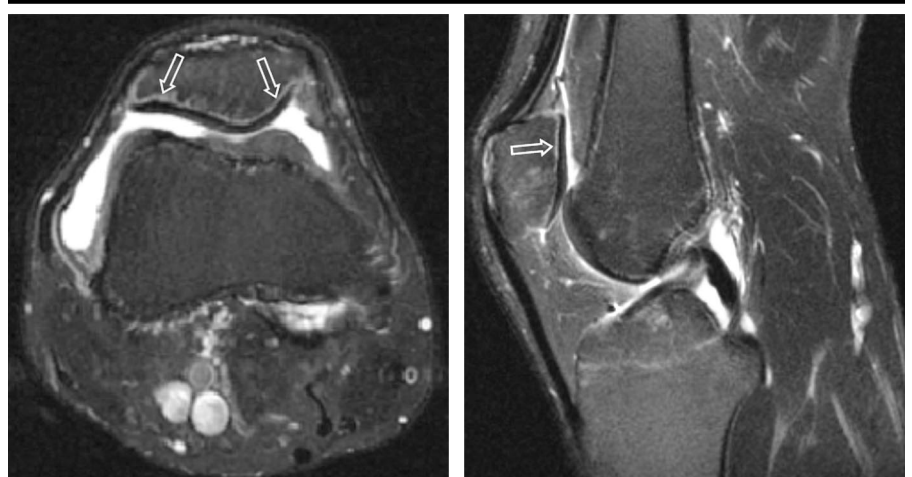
(a) Transverse and (b) sagittal T2-weighted fast SE MR images obtained with fat saturation (3500/68.4) in a 30-year-old man who was assessed for clinically suspected ACL injury. Increased peripheral signal intensity (arrows in a, arrow in b) is noted in the subcortical part of the patella.
